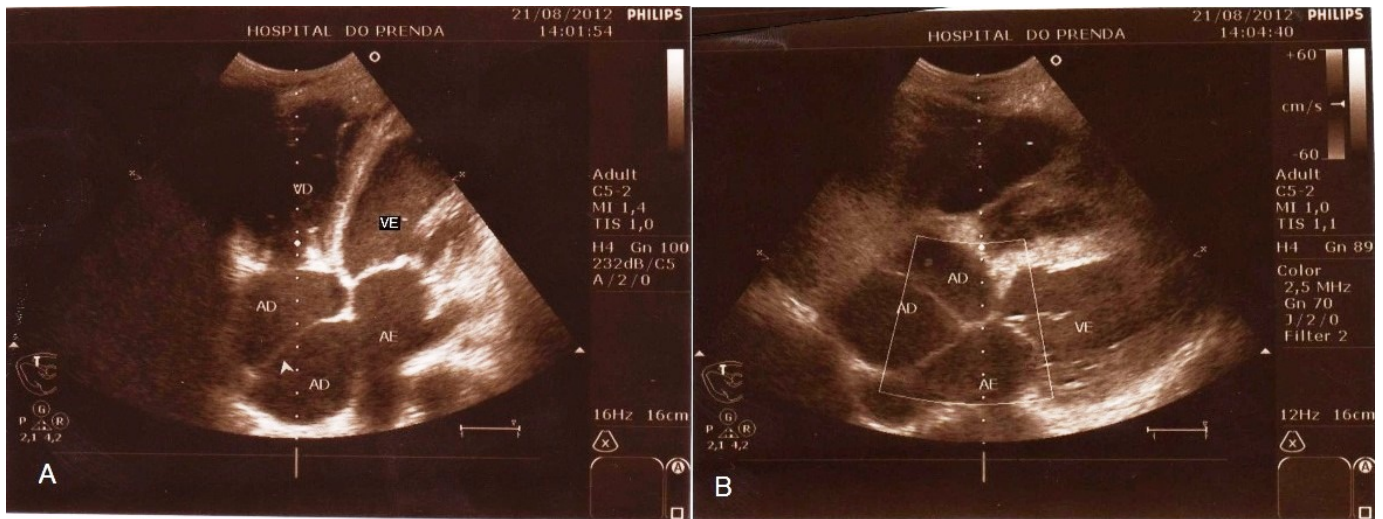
Transthoracic echocardiography. A. Apical four-chamber view. B. Subcostal view. Shows the membrane that divides the right atrium into two cavities (arrowhead). AD: right atrium, AE: left atrium, VD: right ventricle, VE: left ventricle
